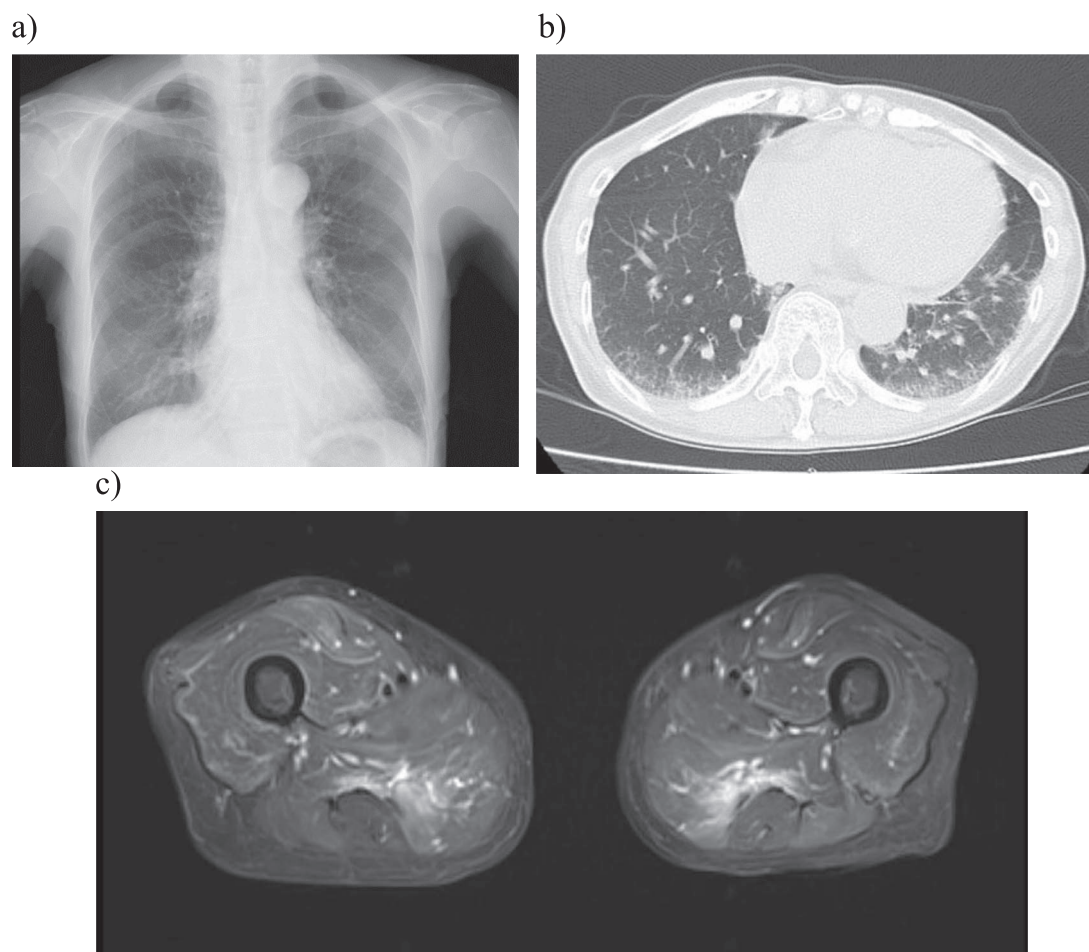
Imaging findings. (a) Chest radiography findings on Day 3. (b) Computed tomography (CT) findings of the chest 16 days before admission. (c) Simple magnetic resonance imaging findings of the thigh on Day 6 of admission (fat suppression). High signal intensity was observed in both adductor magnus muscles on Short Tau Inversion Recovery (STIR), consistent with myositis.
